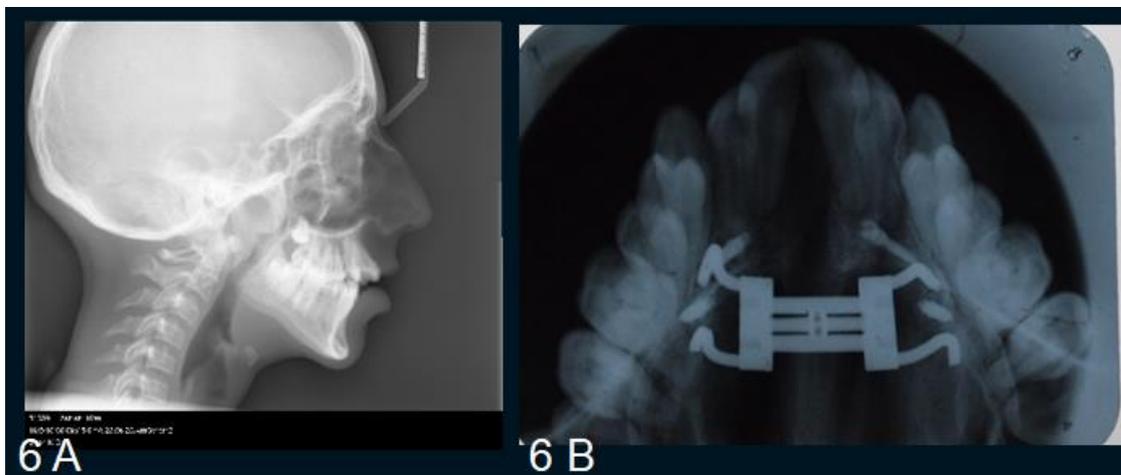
(A-B): POST EXPANSION LATERAL CEPHALOGRAM AND OCCLUSAL RADIOGRAPH
